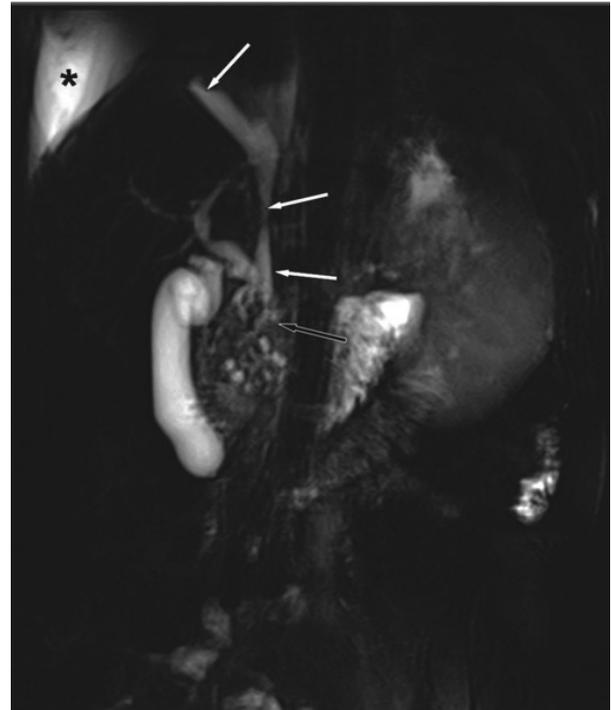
The T2-weighted 2D half-Fourier acquisition single-shot turbo spin echo (HASTE) coronal images showing fistulous communication (white arrows) extending from the pancreatic head region (black arrow) to the right pleural cavity which shows moderate effusion (asterisk). In addition, irregular dilations of the pancreatic duct side branches are also seen in the head region of pancreas.
